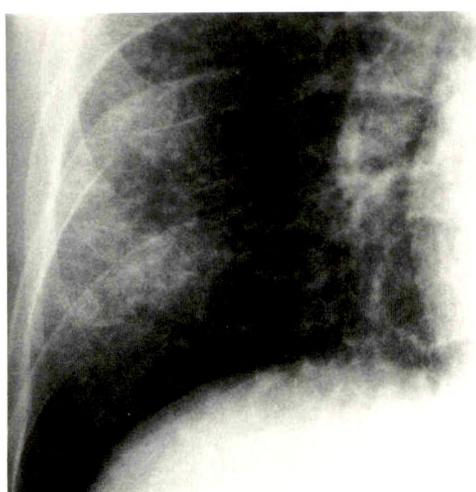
39-year-old man with disseminated histoplasmosis and newly diagnosed AIDS. Clinically, no evidence of fluid overload or heart failure was found. Collimated chest radiograph view of base of right lung shows nodular opacities with associated Kerley's B lines.
